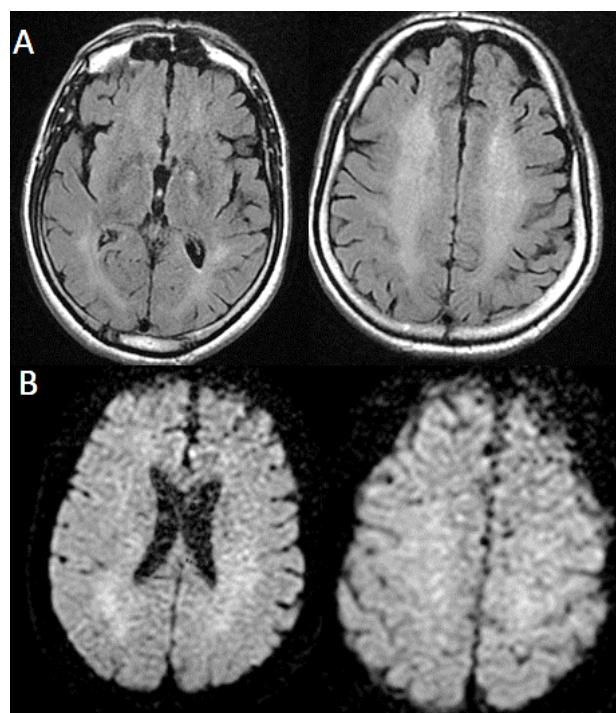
Brain MRI showing mild regression of hyperintensities and apparition of brain atrophy on the axial FLAIR (A) and proton density-weighted images (B).
